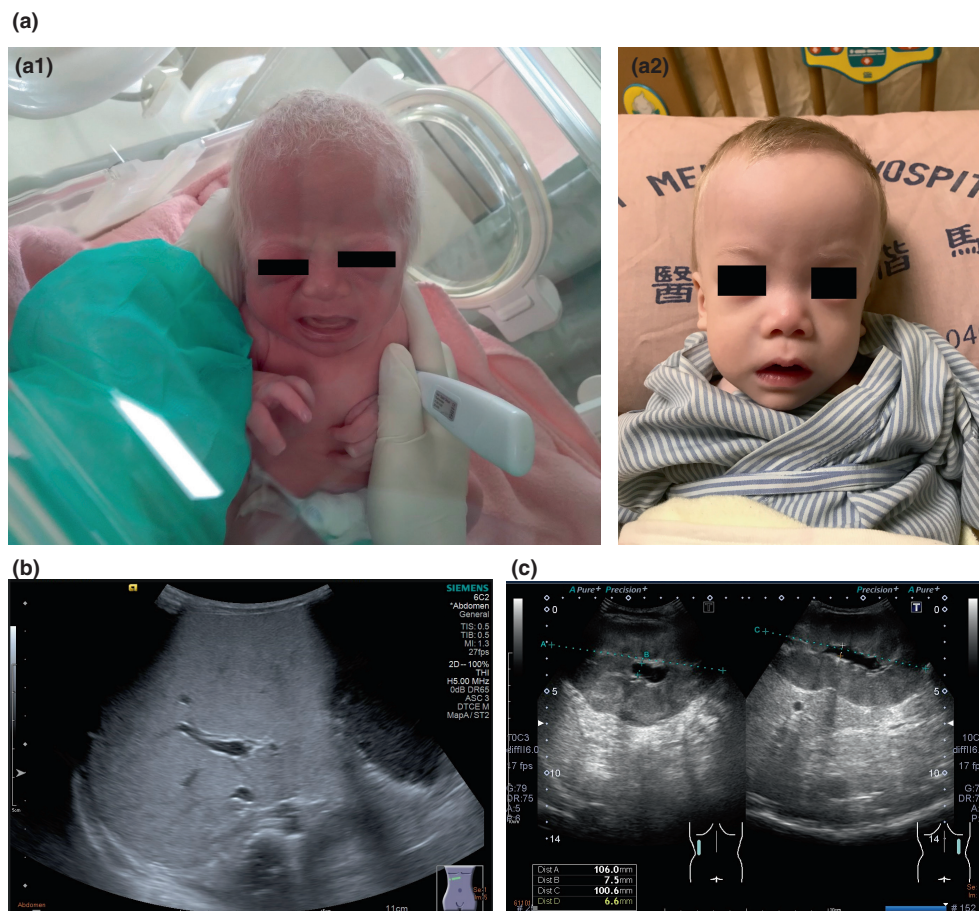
Clinical and radiological findings in the patient. (a) Patient showing hypopigmentation of the skin and hair. (a1) Birth (a2) 2-year-old (b) Abdominal ultrasonography demonstrating diffuse and homogeneous increased echogenicity of the liver. (c) Renal ultrasonography showing bilateral nephromegaly with increased echogenicity and poor corticomedullary differentiation.
